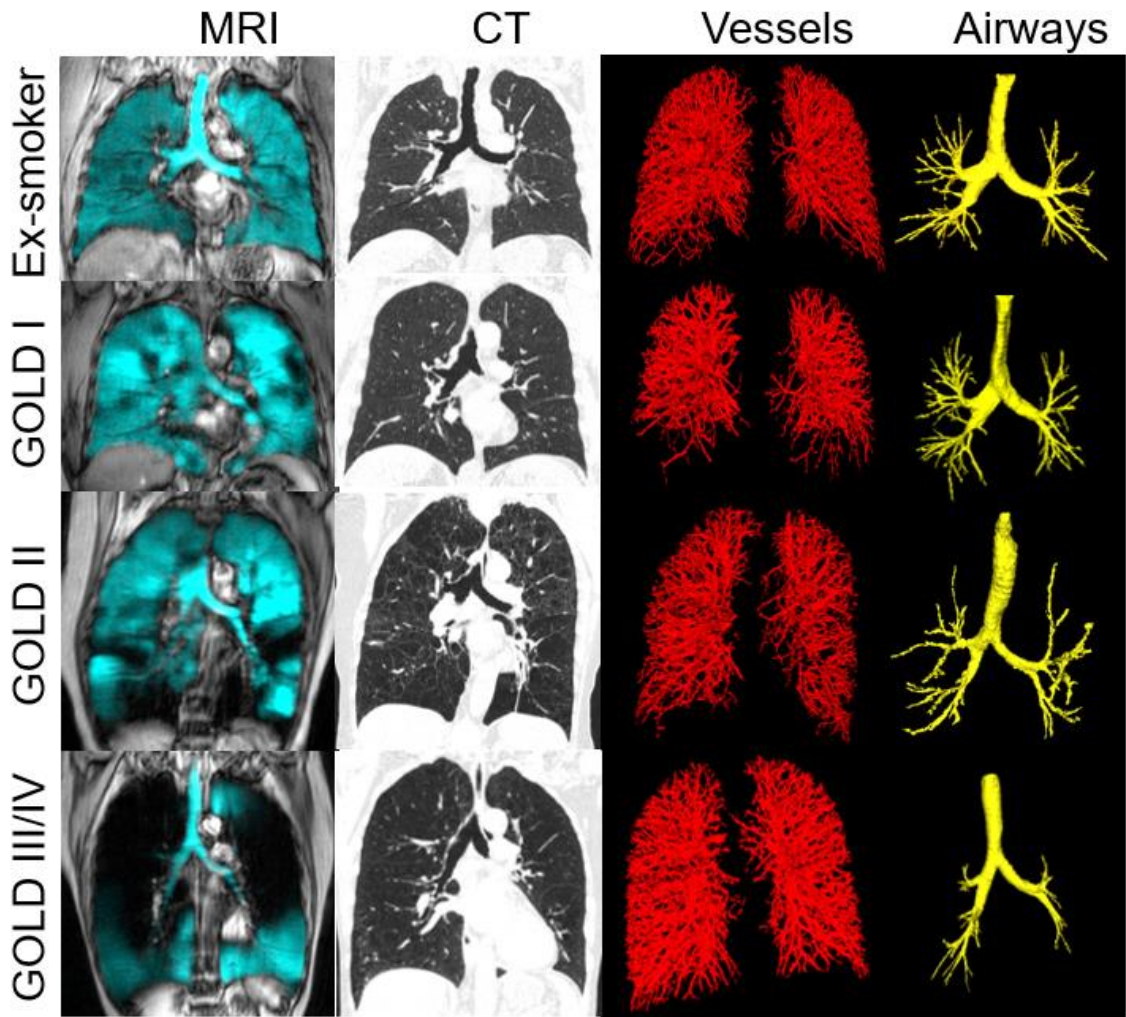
³He MRI and computed tomography images and 3D models of vascular structure and airways in an ex-smoker without COPD as well as participants COPD. Left panel: chest CT in an ex-smoker without COPD, as well as representative participants with GOLD I, II and III/IV COPD. Middle panel: 3D rendering of vascular trees. Right panel: 3D rendering of airway trees demonstrating a decrease in the number of airways with increasing disease severity.
